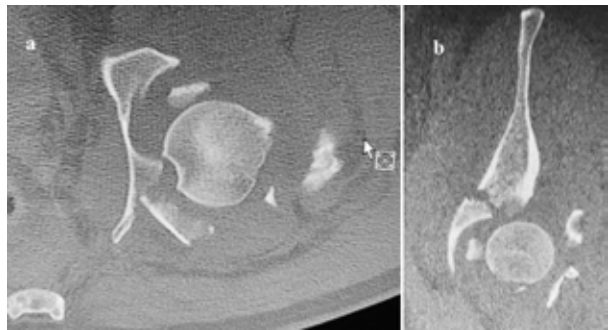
Case 1 CT scan. a) axial view showing bi-columnar fracture with significant comminution and head posterior dislocation, b) Sagittal view showing transverse fracture
